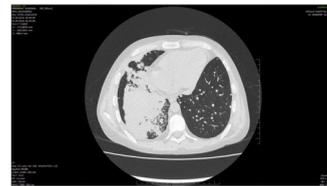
HRCT thorax (one cut) showed collapse consolidation in right lower lobe
